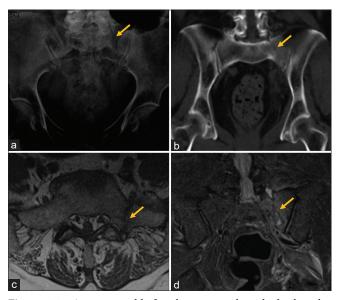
A 75-year-old female presented with back ache. (a) Initial anteroposterior radiograph of the pelvis shows fracture line (arrow) through the left sacral ala. (b) Coronal reformatted CT image of the pelvis also demonstrates fracture line (arrow). (c) Axial T1W image shows an irregular hypointense fracture line (arrow). (d) Coronal STIR image demonstrates a hypointense fracture line with surrounding hyperintensity (arrow) in the left sacral ala.
